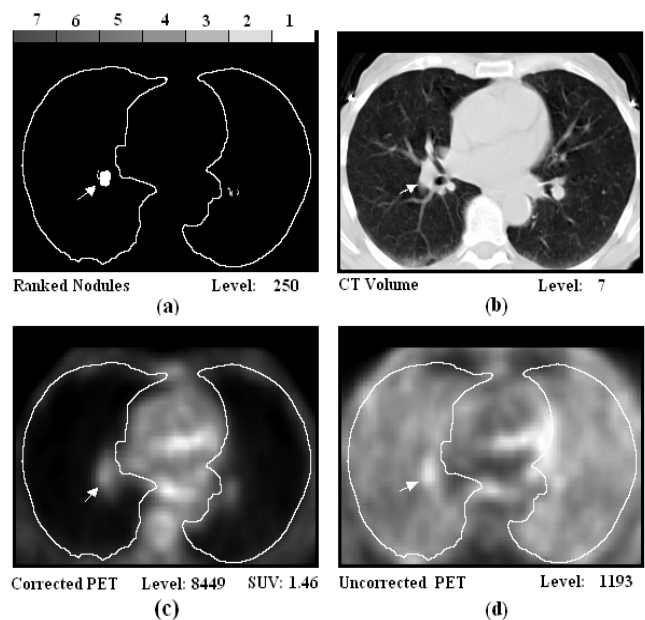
(a) tumor matching Rule 1 is marked and assigned the highest score. Corresponding locations as well as intensity and SUV values are shown in (b) CT (c) AC-PET and (d) AU-PET. The bar on the top of (a) shows the encoding of rule numbers into gray levels.
